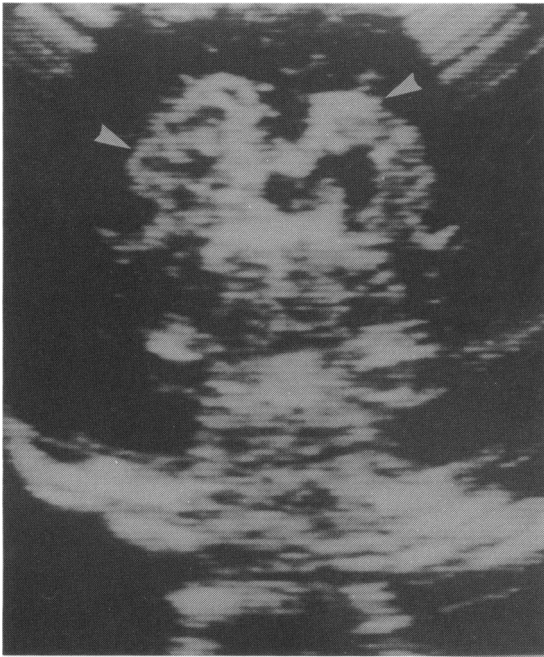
Cerebral ultrasound scan in index case. This shows periventricular echogenic haloes (arrows) with absence of echoes above this region (black area), suggesting sclerotic calcification and infarction of the parietal lobe.
